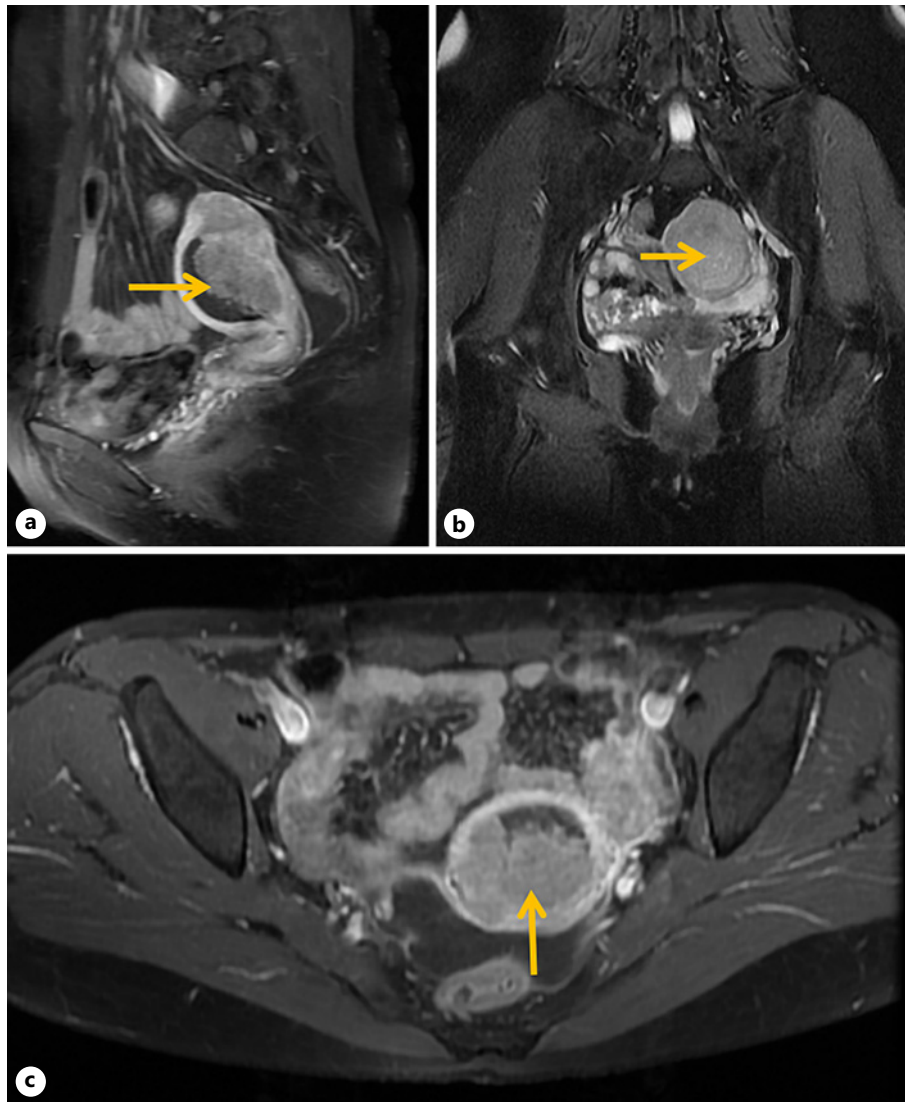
a MRI. b Sagittal section. c Coronal section. Cross section shows an endometrial mass.
